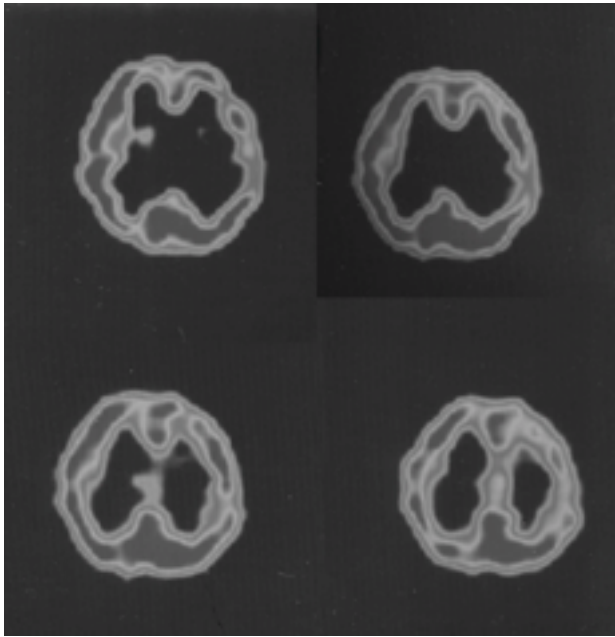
Brain SPECT using Tc-99m ECD revealed decreased perfusion of the left parietal cortex.
